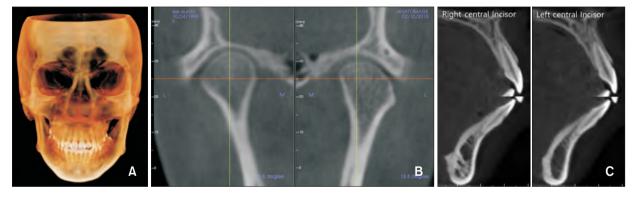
Initial frontal image of skull (A), coronal image of TMJ (B), sagittal image of incisors using CBCT (C).
